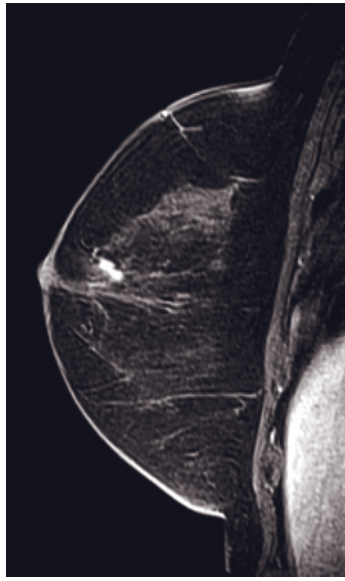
MRI-guided core biopsy. MRI-guided core biopsy and marker clip placement was performed with a dedicated biopsy system and a workstation. Postcontrast T1-weighted axial (*a*) and subtracted (*b*) images demonstrate an enhancing mass in the subareolar region. Note that to facilitate the biopsy the breast was positioned to maximize the breast thickness anteriorly, where the targeted lesion was located. A sagittal postcontrast T1-weighted scan (*c*, *d*) was then obtained to plan the biopsy. A grid compression plate can be seen as a mesh of rectangular signal voids at the skin surface (*d*). This plate contains high-signal markers (not shown here, seen on different images) that were selected on-screen to define a three-dimensional frame of reference. After the target was identified and marked on the postcontrast images, its location, i.e., the skin incision coordinates in the grid relative to the marker position, and the target's depth from the surface were automatically calculated. The stylet was introduced through the coaxial sheath and then replaced with a plastic localizing obturator. An obturator is seen as a round (*e*), or linear (*f*) signal void. Its position relative to the targeted enhancing mass can be easily determined. On the sagittal scan (*e*), it is located within the mass. On the axial scan (*f*), it is obvious that its tip passed the lesion. Therefore, the coaxial sheath had to be retracted about 4 mm before the obturator was replaced by the biopsy needle and biopsy was performed. After the biopsy, a marker clip was placed at the biopsy site. A marker clip's signal void is seen on both sagittal (*g*) and axial (*h*) postprocedural scans. The marker clip is located at the medial edge of the enhancing mass (*h*). The obturator is again seen (*h*), now pulled back even more. Pathology confirmed IDC.
